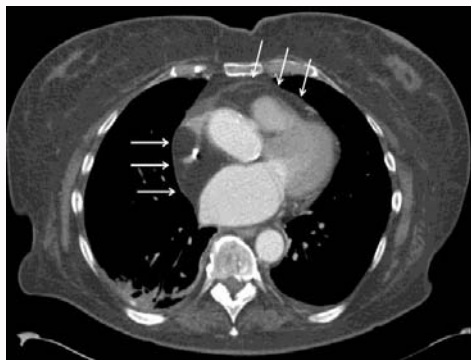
Contrast enhanced axial CT image demonstrates fat density tissue (-90 Hounsfield units) arising from the interatrial septum which circumferentially narrows the lower SVC and proximal right atrium. Fat density tissue extends to the lateral right atrial wall and anteriorly along the right ventricular outflow tract (arrows). Post-processing revealed the cavoatrial lumen to measure 0.65 cm² area (normal 6.79- 10.02 cm²)(8) with the catheter tip occupying approximately 0.23 cm².
